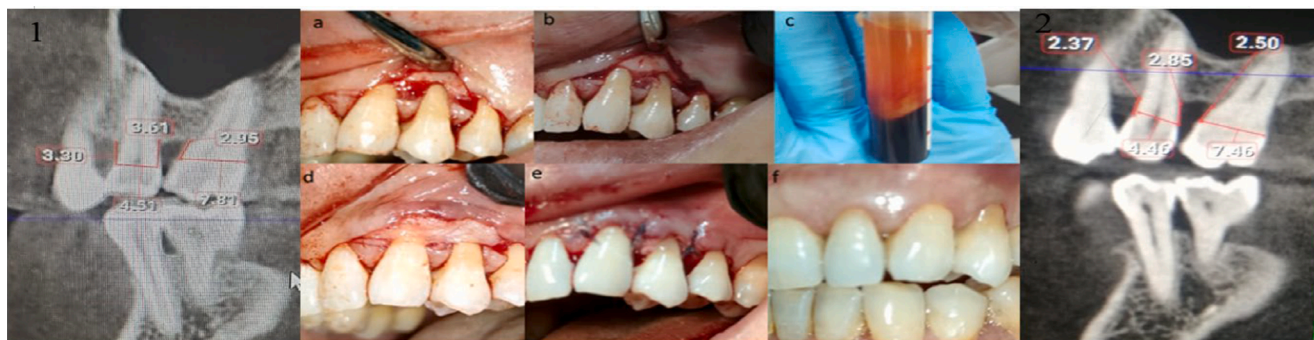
(1) CBCT sagittal cut showing measurement of supra bony defect before treatment. (a) a horizontal, butt-joint incision was performed 1–2 mm coronal to the bone crest. (b) a buccal mucoperiosteal envelope flap (SFA) was elevated, and the defect was debrided manually. (c) CGF preparation. (d), defects were filled with CGF between the roots inter-proximal below the undetached papilla and extending to cover the root surface buccally. (e) a horizontal internal mattress suture. (f) 21-day healing. (2) CBCT sagittal cut showing measurement of supra bony defect 6 months after treatment.
